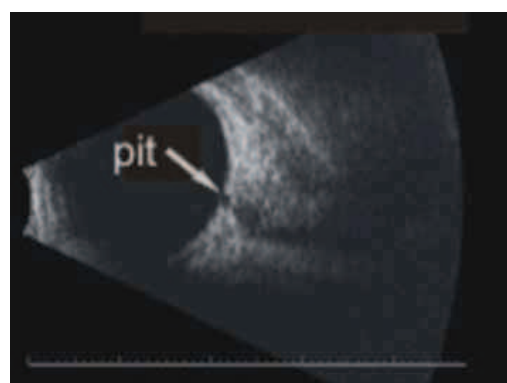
Ultrasound B scan optic disc pit
